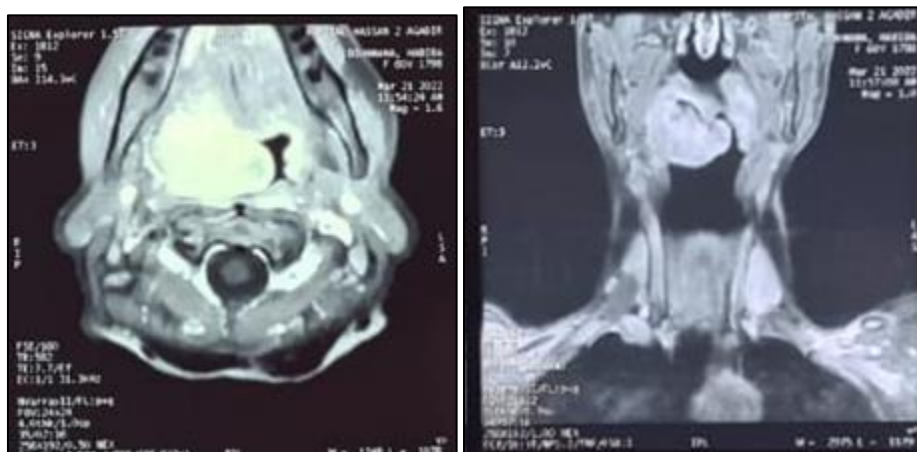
MRI with axial (left) and coronal (right) images showing a hyperintense tumor of the right tonsil
